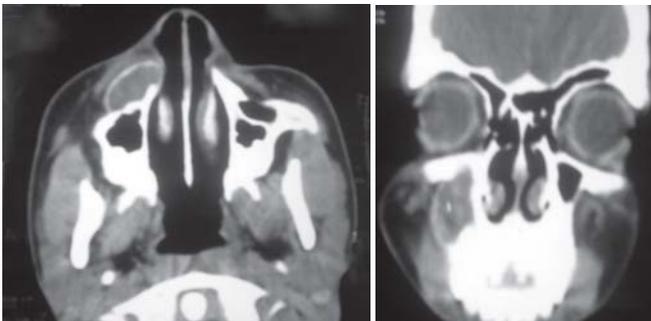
CT Scan of maxilla (axial/coronal)
